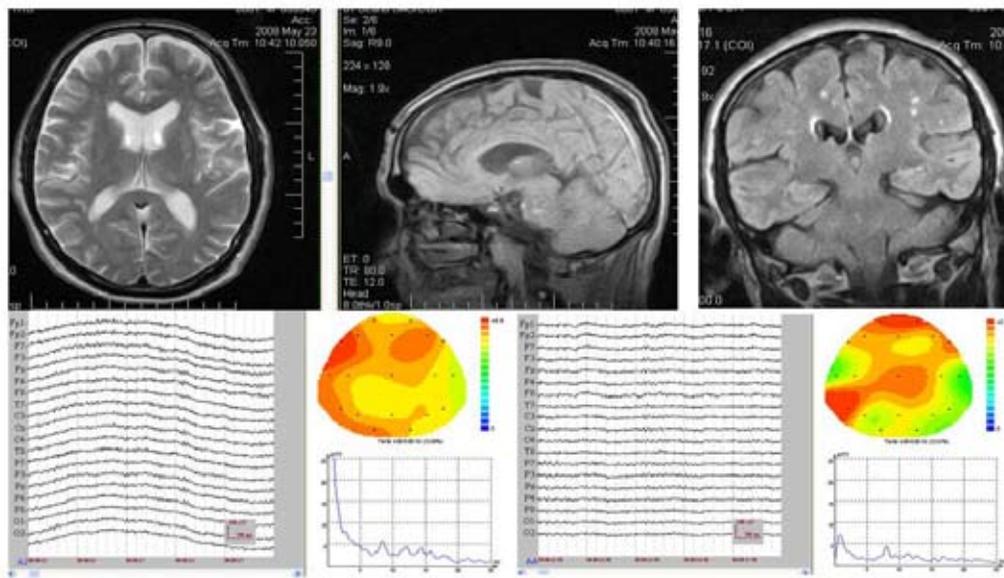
MRI and brain mapping activity (pre- vs post-treatment with a multifactorial therapy) in an AD-*APOE-3/3* carrier.
